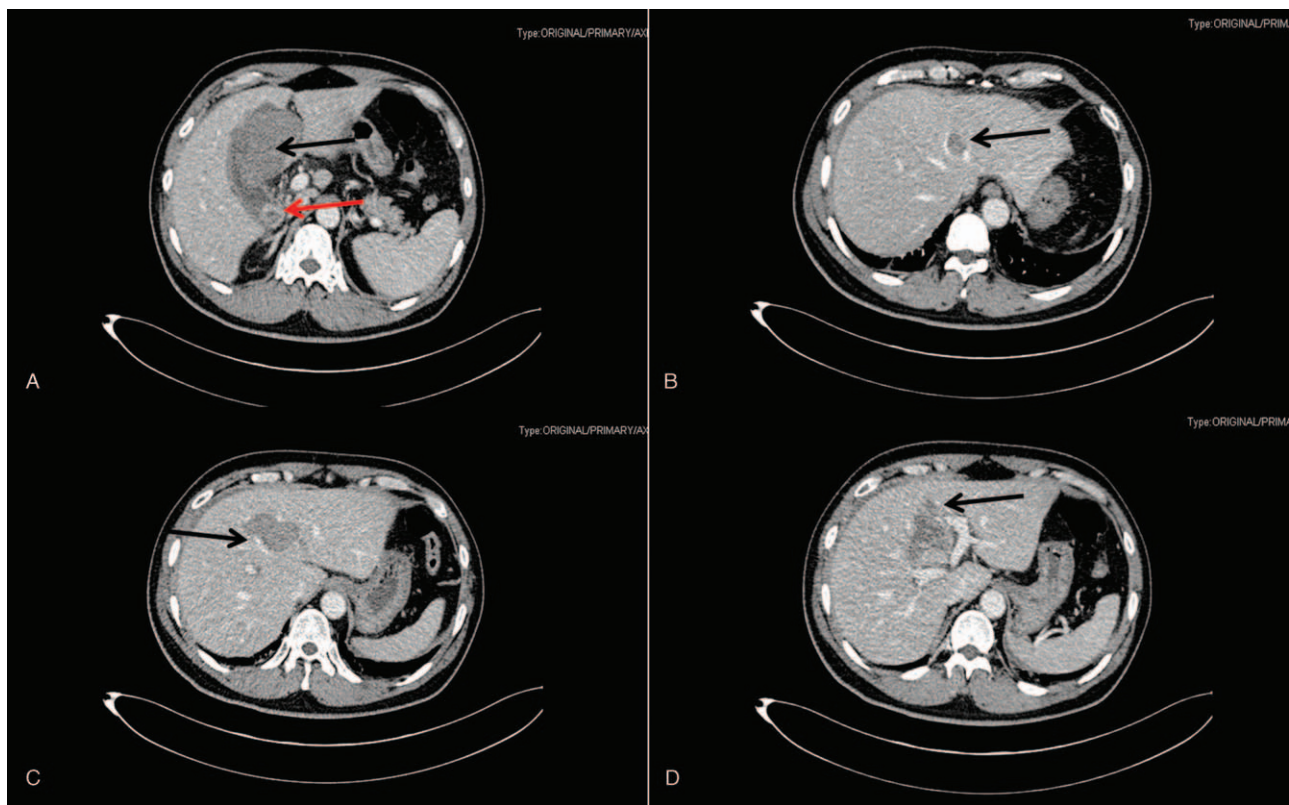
CT image of this patient's liver mass. A. The liver mass has "invaded" into the gall bladder (black arrow). The cholecystolithiasis is presented in CT scan (red arrow); B. The top of the liver mass has "invaded" the left hepatic vein (black arrow); C. The liver mass has "invaded" the middle hepatic vein (black arrow); D. The liver mass has "invaded" the portal vein of segment IV (black arrow).
